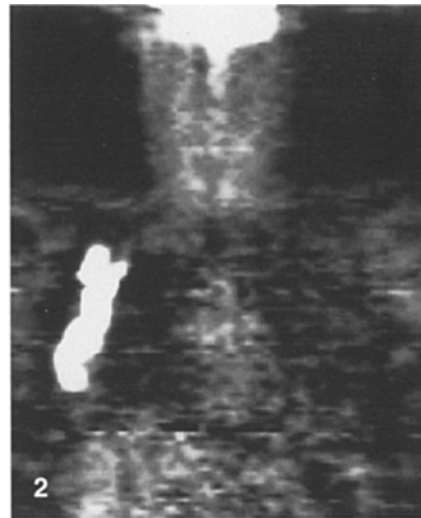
Anterior ^{18}F -FDG PET images showing intense uptake in nodal metastases in the right axilla (true-positive finding)
